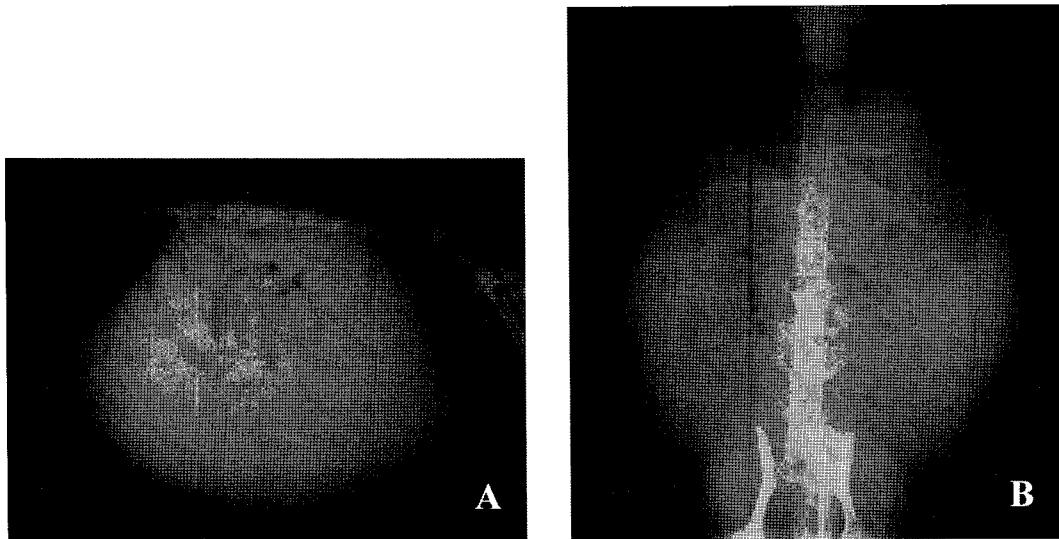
Diffuse loss of abdominal details including floating gas-filled intestinal structures and severe abdominal distension from right lateral (A) and ventrodorsal (B) abdominal radiographs.
